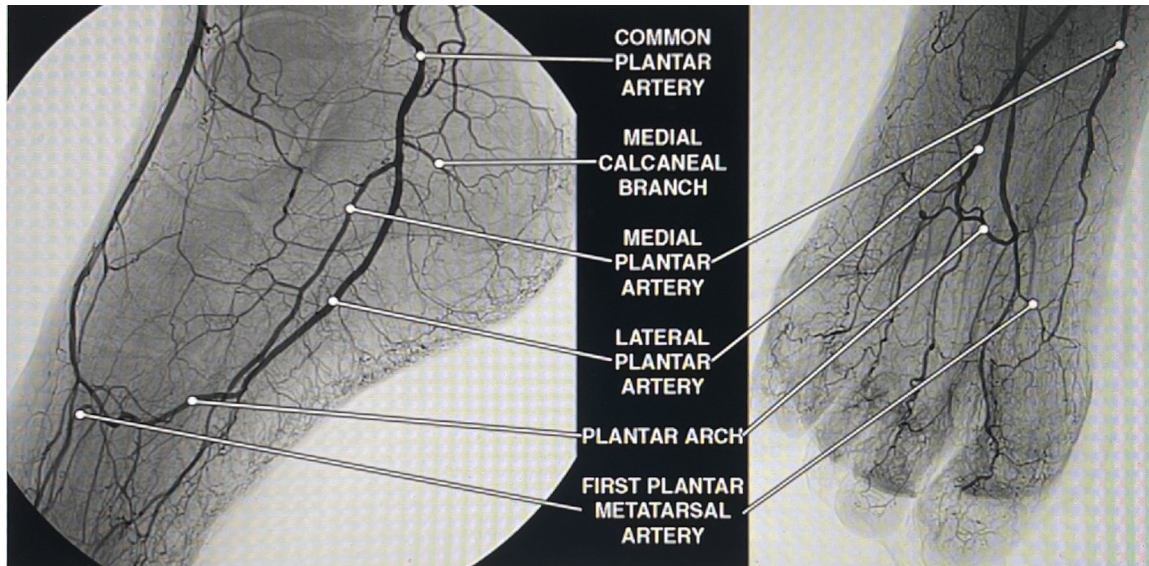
Posterior circulation of the foot. Lateral view (left image) and anterior-posterior view (right image). From Manzi M, Cester G, Palena LM, et al. Vascular imaging of the foot: the first step toward endovascular recanalization. *Radiographics* 2011;31:1623–36 [22], adapted with permission.
